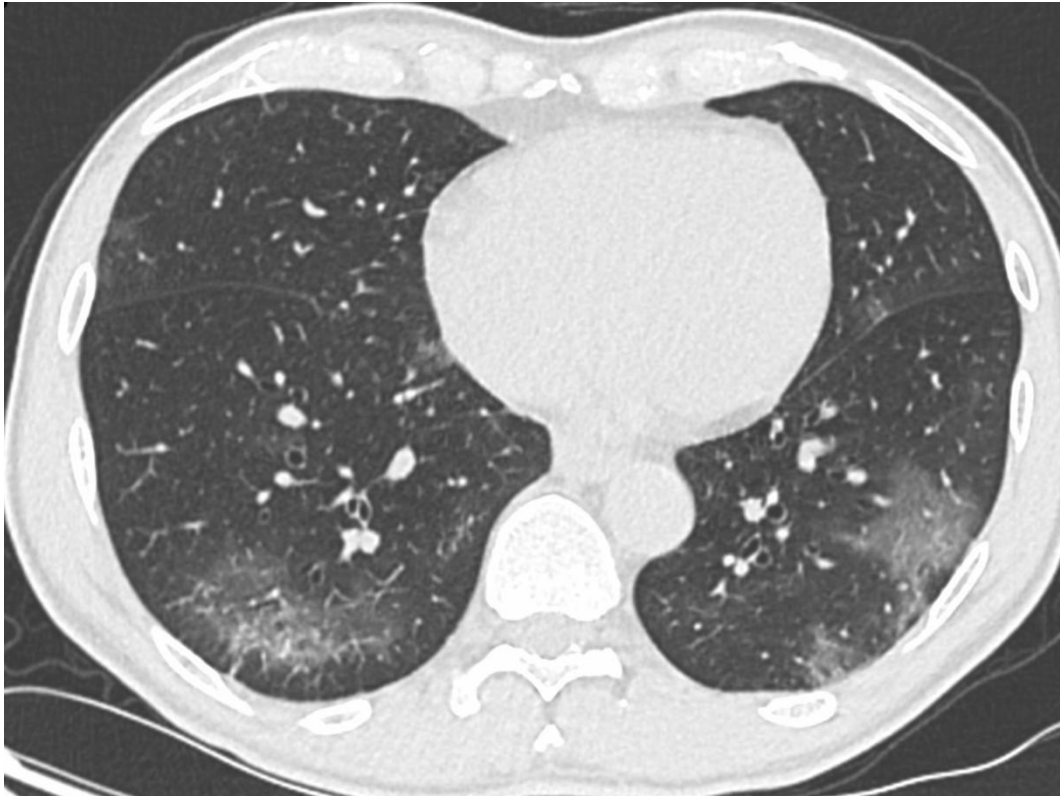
Chest CT scan without injection in axial sections: bilateral ground-glass areas (arrows)
